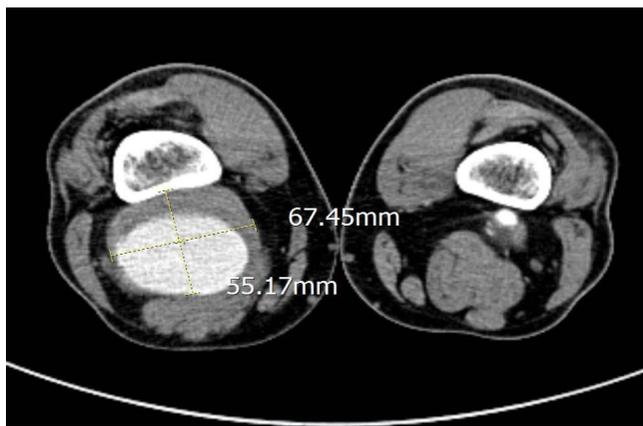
CT image of the mass
